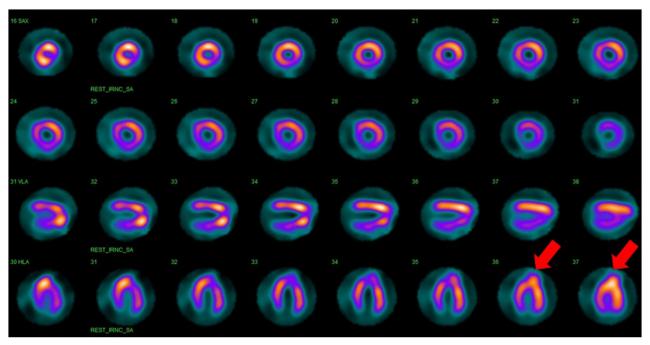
Rest SPECT MPI with short-axis (SAX; top two rows), vertical long-axis (VLS; third row; apical 2-chamber equivalent), and horizontal long-axis (HLA; bottom row; apical 4-chamber equivalent) displays demonstrates an apical perfusion abnormality with an outpouching seen particularly in the HLA views with radiotracer uptake seen within the walls of outpouching myocardium (red arrows).
